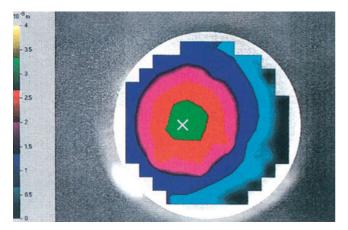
Laser Doppler scanning vibrometry of a cartilage-perichondrial plate. The amplitude peak of the homogeneous plate is located at the center (green area). The frequency curve is plotted at the position of the white cursor (see Fig. 2.18).
